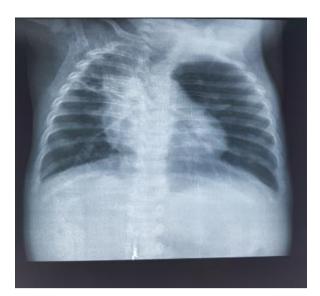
Frontal chest X-ray 2 months after treatment showed early upper lobar atrophy with tracheal ascent, thickening and retraction
